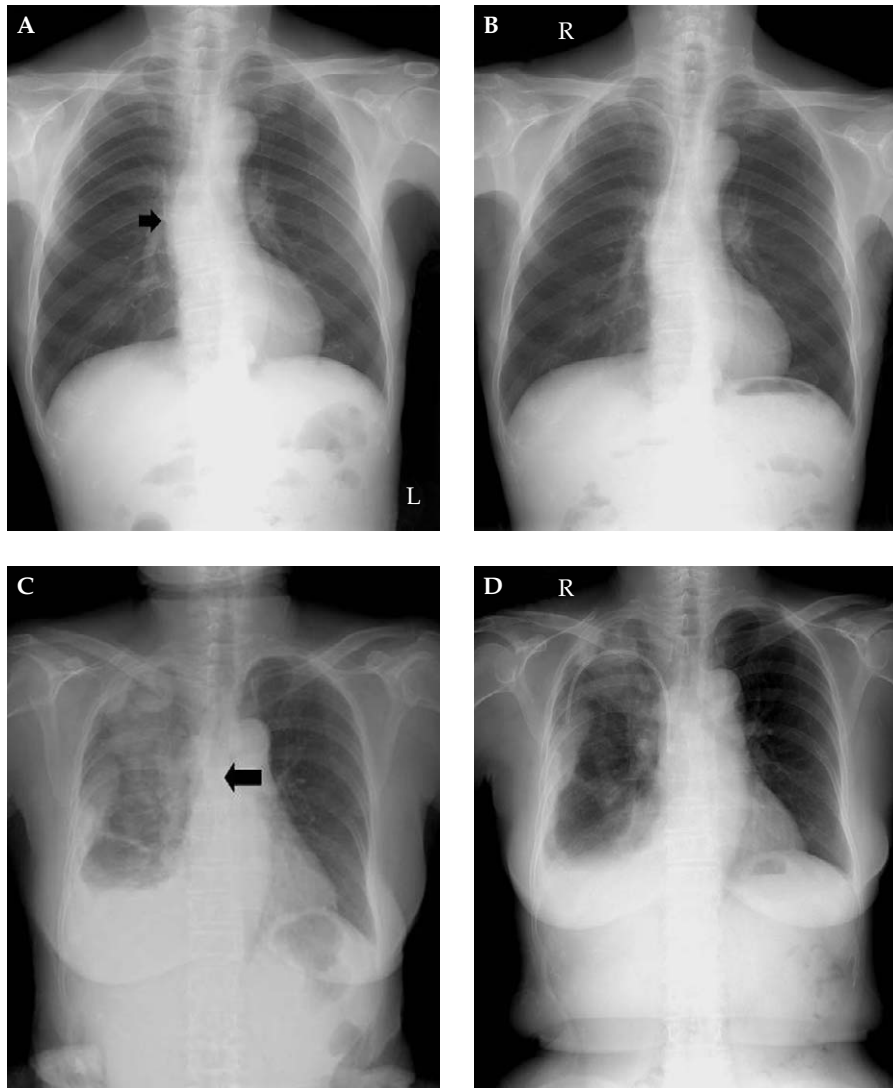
Perioperative chest radiographs in two patients without radiographic superior vena cava–right atrium (SVC-RA) junctions. (A) The preoperative radiograph of a patient with tortuous ascending aorta (arrow) that blunted the SVC-RA junction. (B) The postoperative radiograph of the same patient after implantation of a permanent central venous catheter. (C) The preoperative radiograph of a patient with gastric cancer and diffuse pulmonary metastasis (arrow) that blunted the SVC-RA junction. (D) The postoperative radiograph of the same patient.
